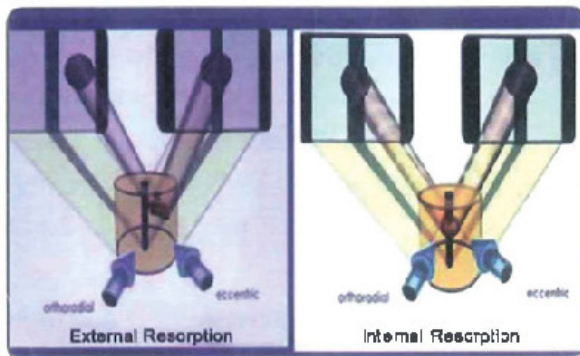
Mesial or distal X-ray shift technique to differentiate type of root resorption. Internal resorption, the defect does not change position with change in X-ray angulation (right side). External resorption, the defect changes position (left side).
